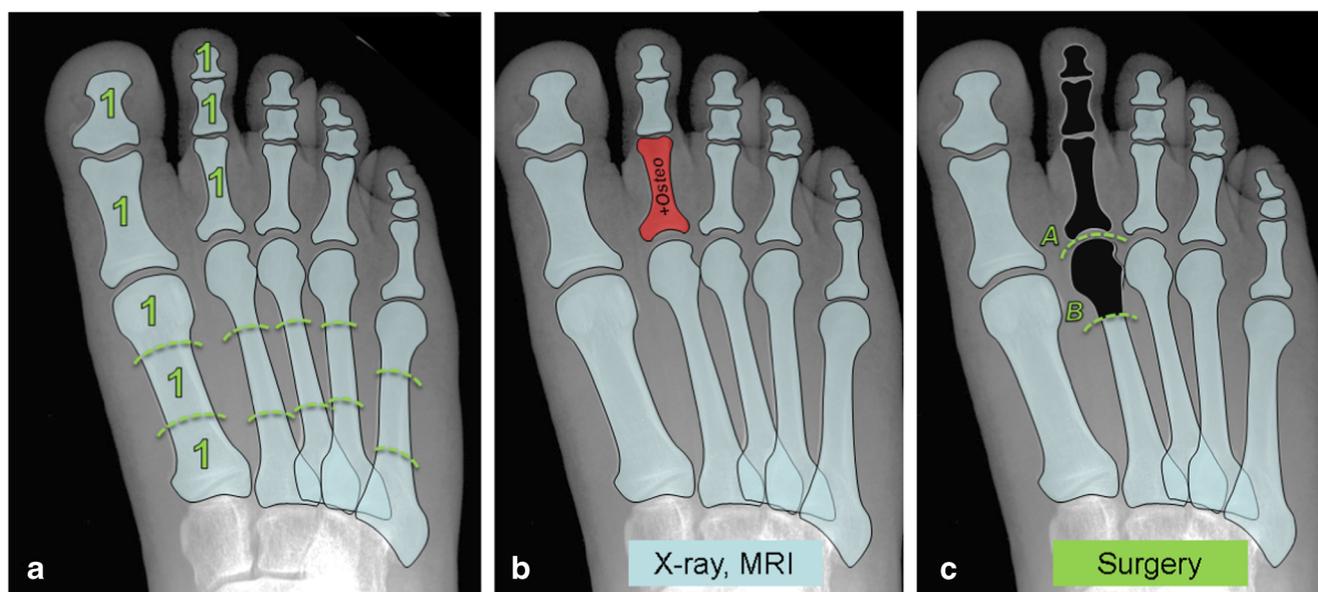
Scoring system for disease extent and definition of surgical agreement. a Point score system to record the extent of disease, one point was allocated for each phalanx and for one-third of a metatarsal shaft where osteomyelitis was reported. Quantitative agreement between X-ray and MRI was determined as a difference in the point score between both modalities when both demonstrated the presence of disease. b, c Agreement between each imaging modality and surgery was defined as
